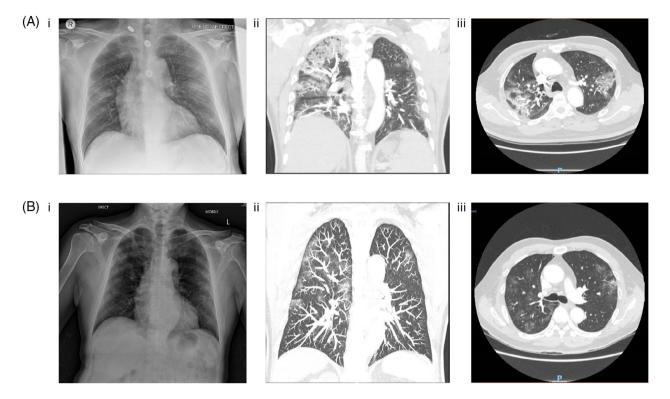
Chest radiographs and computed tomography (CT) images of the two patients from Victoria (VIC-5 and VIC-6) with COVID-19. (A): (i) Chest radiograph on admission demonstrating subtle ill-defined opacities within the mid zones bilaterally and left lower zone; (ii) Day 4 chest CT (coronal maximum intensity projection, MIP); and (iii) Day 4 chest CT axial demonstrating extensive ground-glass opacities in a peribronchovascular and peripheral distribution favouring mid to upper zones of the lungs. (B): (i) Chest radiograph on Day 6 demonstrating patchy opacity within the lateral aspect of the right upper lobe; (ii) Day 11 chest CT (coronal MIP); and (iii) Day 11 chest CT axial images demonstrating bilateral peripheral upper zone predominant ground-glass opacities (more on the right).
